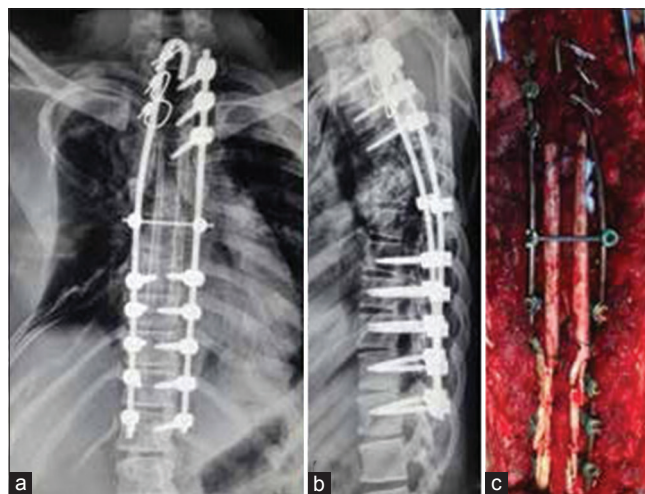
(a and b) Postoperative X-ray dorsal spine anteroposterior and lateral views showing full correction of scoliosis with implant *in situ* (c) Peroperative photograph showing posterior fixation and reconstruction using fibulae
